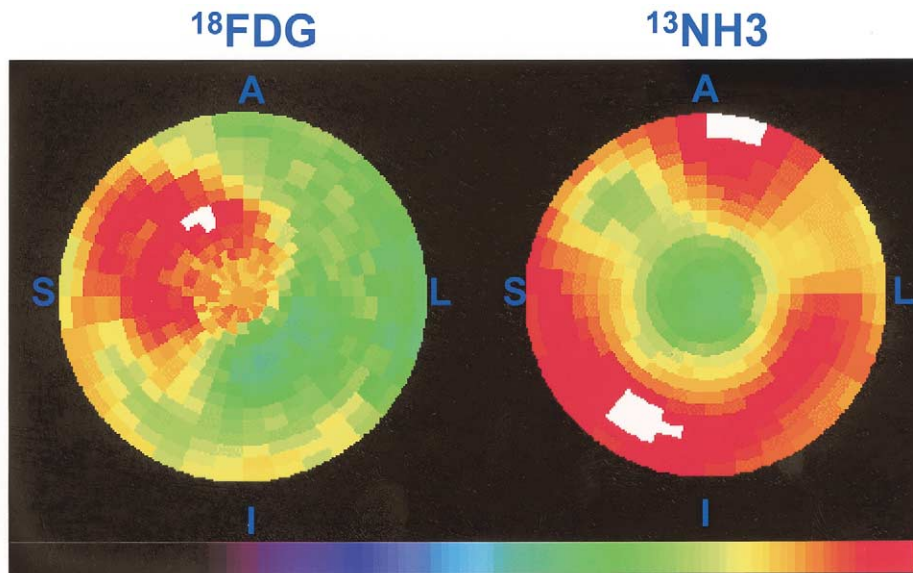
Polar map display of relative myocardial uptake of ^{18}F fluorodeoxyglucose (^{18}FDG) and ^{13}N -labeled ammonia ($^{13}\text{NH}_3$). The most basal LV wall segments are depicted in the most peripheral rings, whereas the most apical occupies the center of the map. S = septum; I = inferior; L = lateral; A = anterior. Segments with brighter colors (white, red) present higher uptake values. There is a large $^{13}\text{NH}_3$ uptake defect in left anterior descending artery territory corresponding to 20% of the left ventricular. In the same area, increased uptake of ^{18}FDG is observed.
